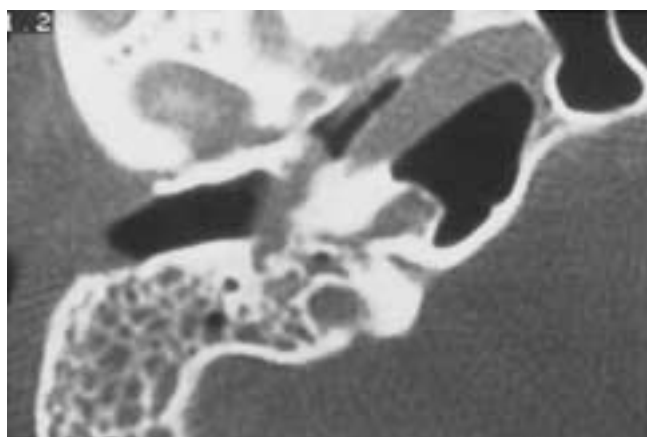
Large glomus tympanicum tumor. Axial CT. Fisch type A tumor too large to be differentiated from glomus jugulare tumor by otoscopy. CT, showing an intact jugular plate, definitely excludes a glomus jugulare tumor. The tumor, extending to the protympanum and obstructing mastoid drainage, is not distinguishable from other benign middle ear tumors by CT. All such tumors can be resected by the transmastoid approach. Angiography is not necessary.
